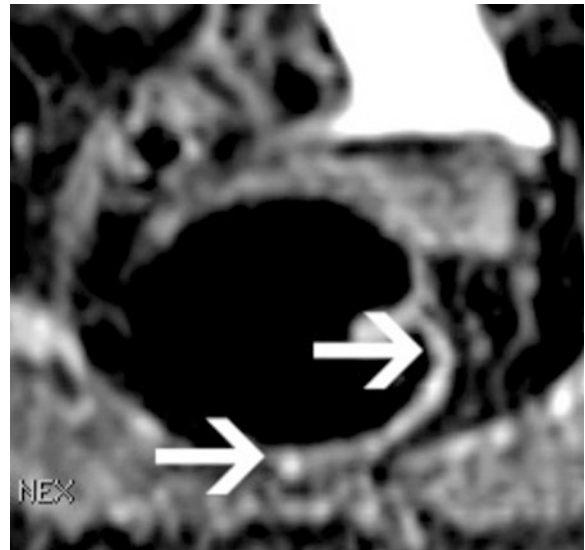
Dark lumen MRC: Coronal subtracted T1-weighted SPGR with subtraction of the precontrast acquisition from 90 s MRC post IV contrast acquisition. Coronal reformatted images shows less than 1 mm elevation of a flat cancer
